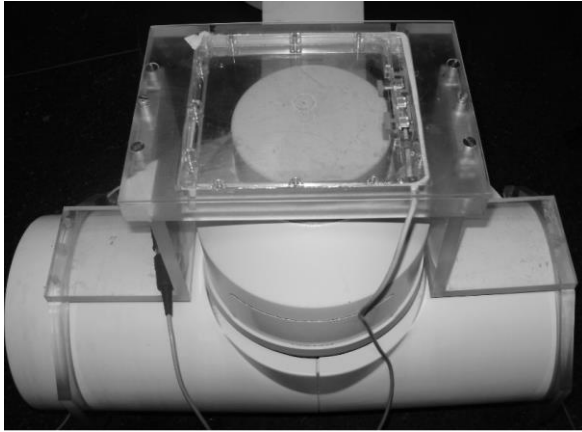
Supports for coupling the chamber to the output of X-ray tube constructed for the equipment.
